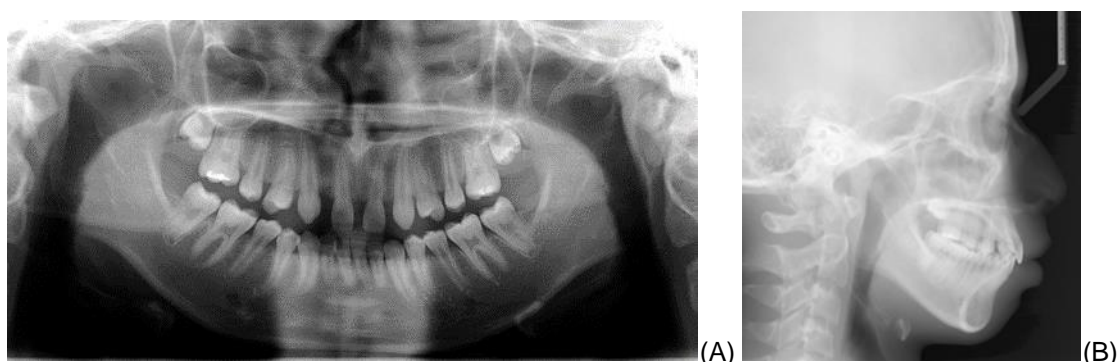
Initial radiograph. (A) panoramic x-ray. (B) Cephalometric x-ray
